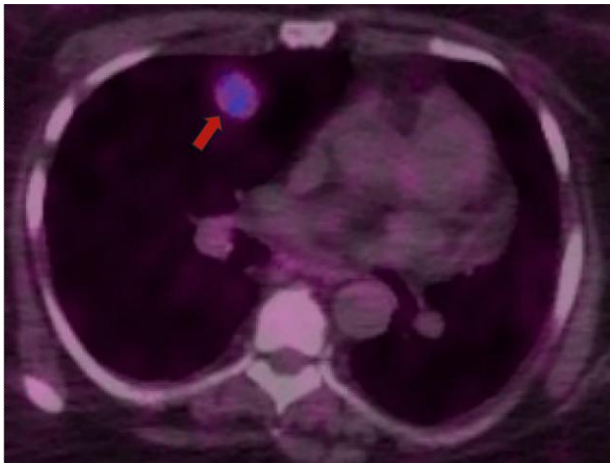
NM Gallium-68 PET/CT from case #2 showing a well-circumscribed 2.1-cm right middle lobe pulmonary nodule with mildly increased DOTATATE uptake.
